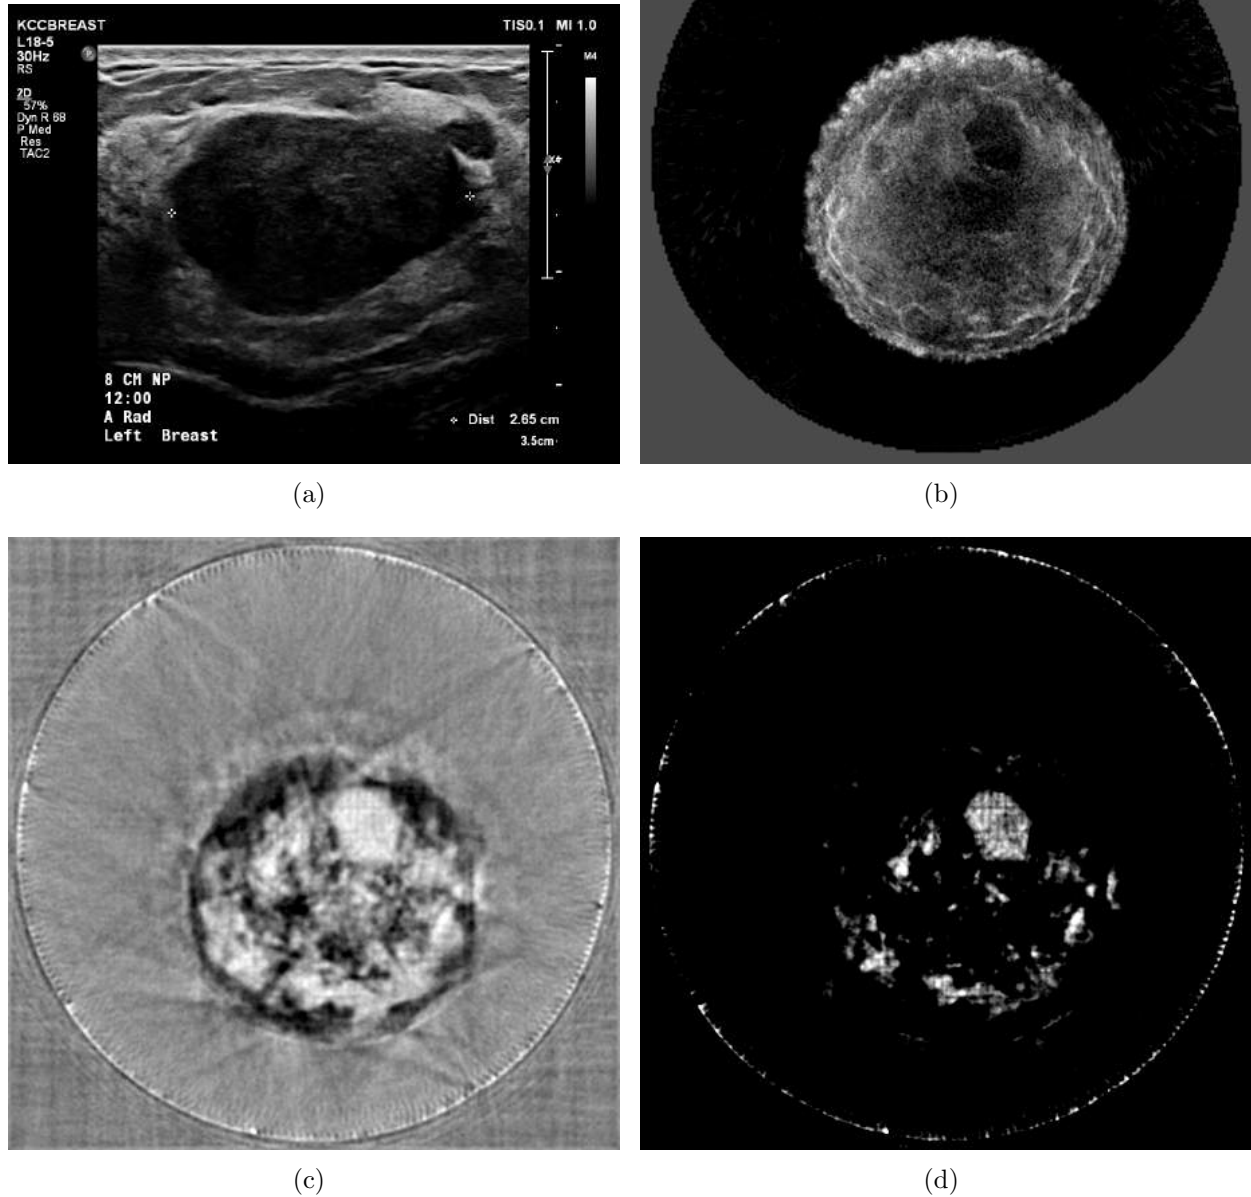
Images Corresponding to Case 2. (a) Hand-Held ultrasound. (b) Reflection envelope. (c) Waveform sound speed. (d) Waveform sound speed with preferential window and leveling.
